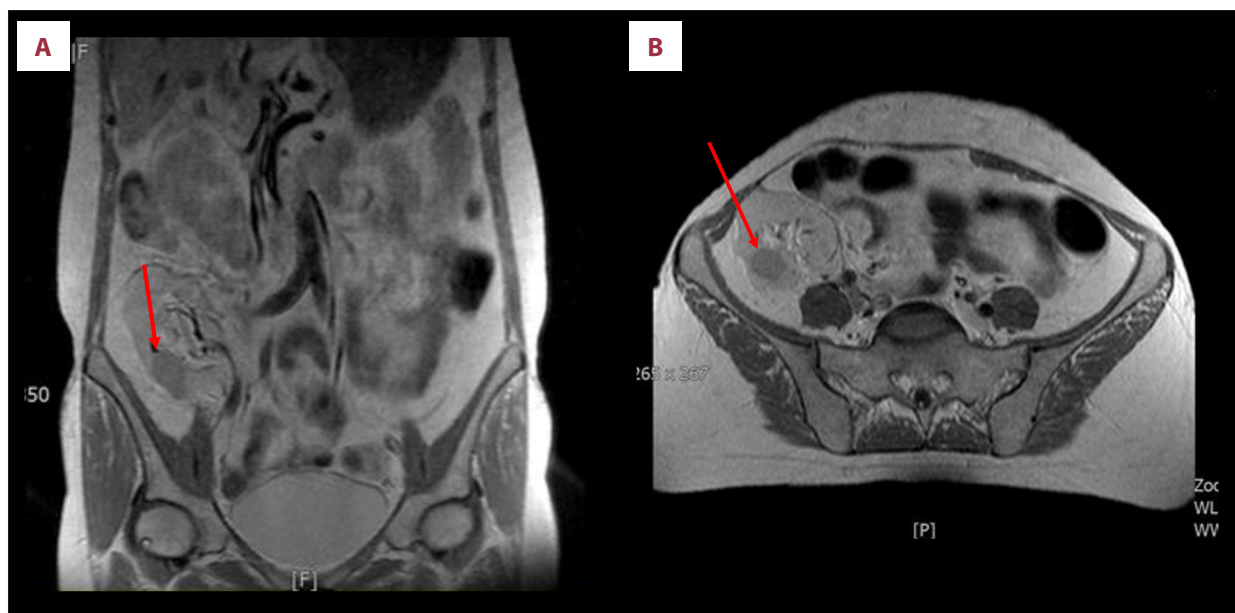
MRI of the abdomen. (A) MRI of the abdomen, frontal view; the tumor of the renal allograft indicated with red arrow. (B) MRI of the abdomen, saggital view; the tumor of the renal allograft indicated with red arrow.
